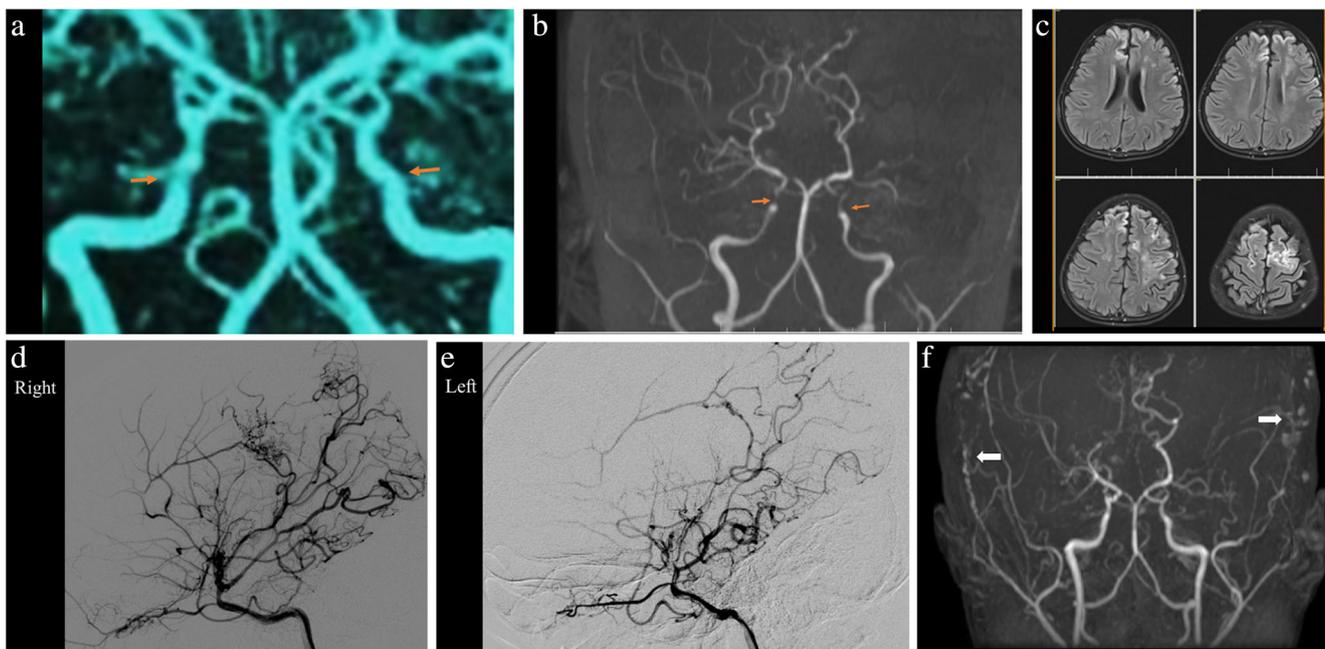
(a) MRA at time of initial stroke showing narrowing of bilateral ICA. (b) MRA, done 2 months later, showing narrowing of ICA, the ICA bifurcation and distal branches. The cortical branches were not visible. Basal perforators were indistinctly made out. (c) MRI brain, done 2 months later, revealed areas of CLN. (d) and (e) Preoperative
